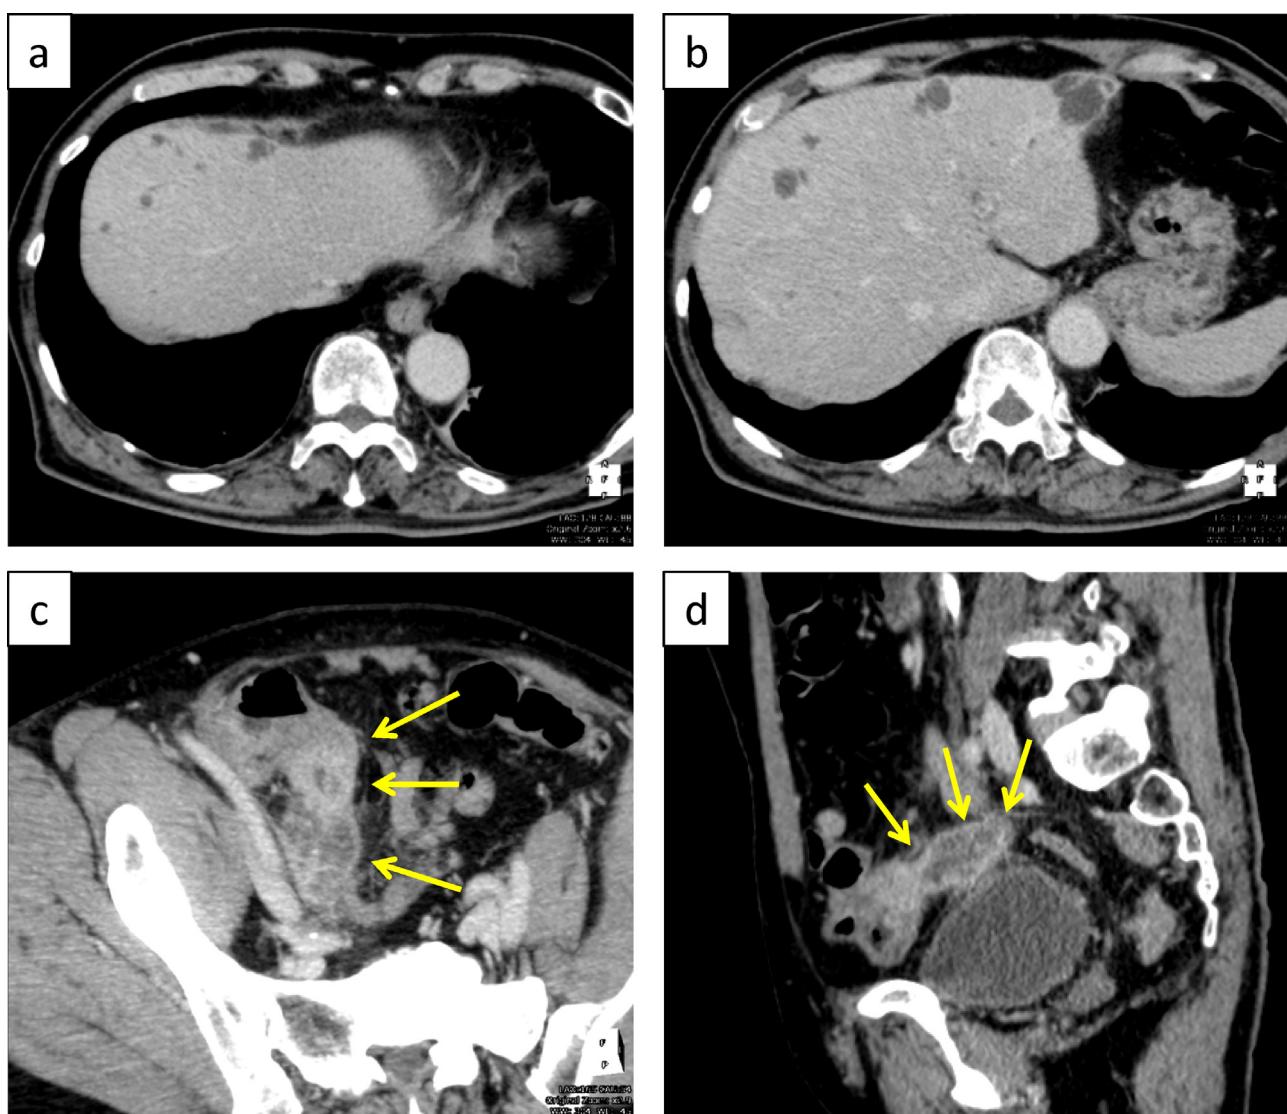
Computed tomography (CT) image.
